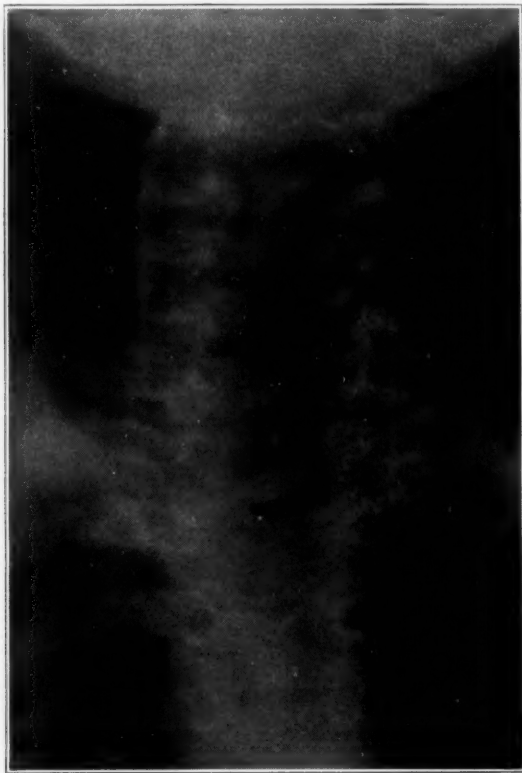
Roentgenogram of the cervical portion of the spine, showing dilatation of the bony canal, flattening of the pedicles and incomplete fusion of the laminae of the seventh cervical and first dorsal vertebrae.
